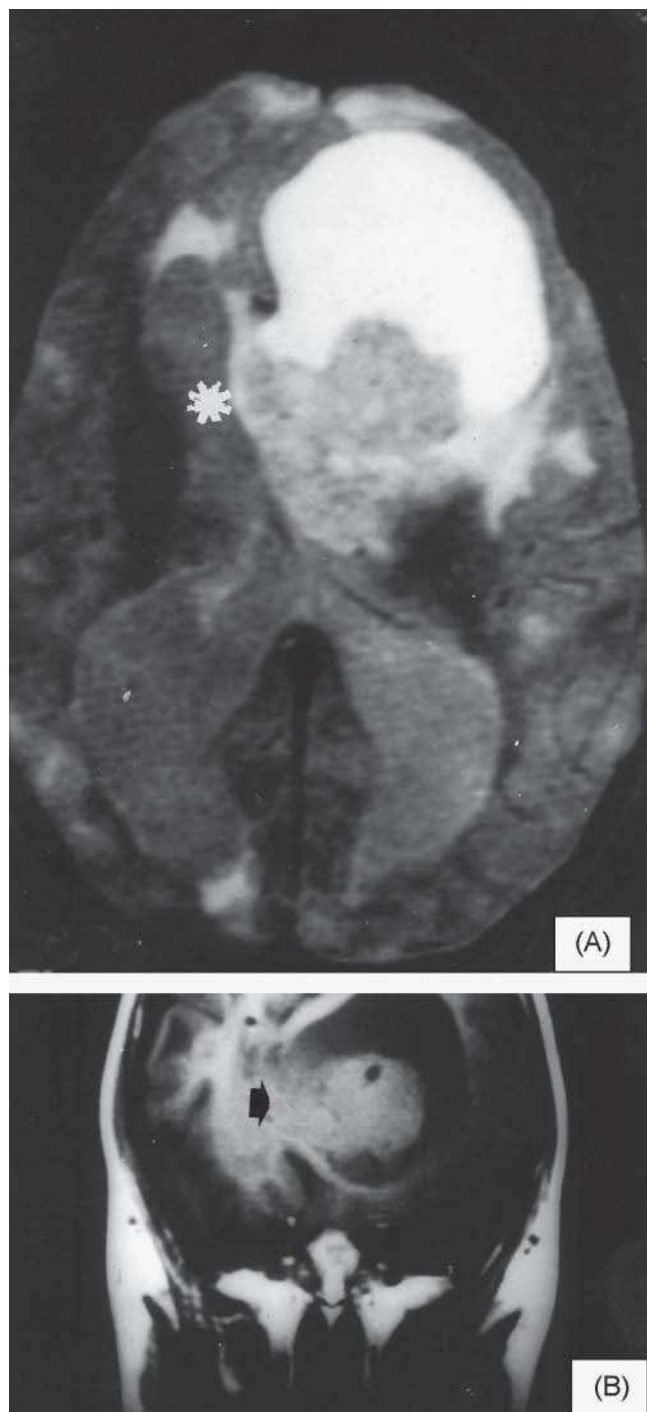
Case 2. Magnetic resonance imaging (MRI) at 9 years. A: axial section of MRI in T2 shows a bulky tumour in the left frontal area with a large external cystic component and an internal solid part (in the region of the foramina of Monro) with invasion of the medial area (asterisk). B: coronal section of the MRI in T1 showing the voluminous cystic (dark) and solid (inner area of the tumour) components with displacement of midline towards the right side (arrow).
